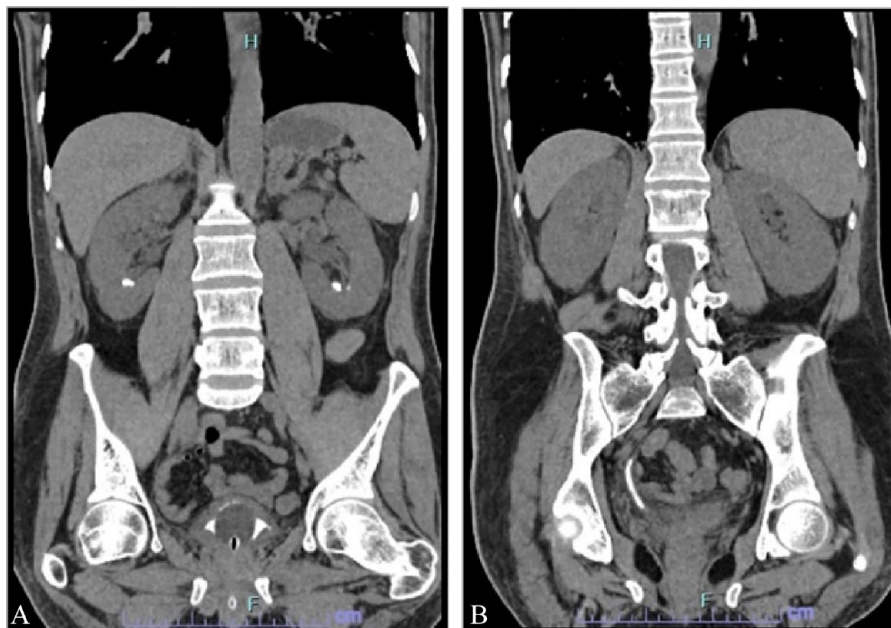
Non-contrasted coronal CT scan images showing multiple hyperdense lesions in both kidneys and urinary bladder (A) and the lower part of the right ureter (B) reported as stones.
